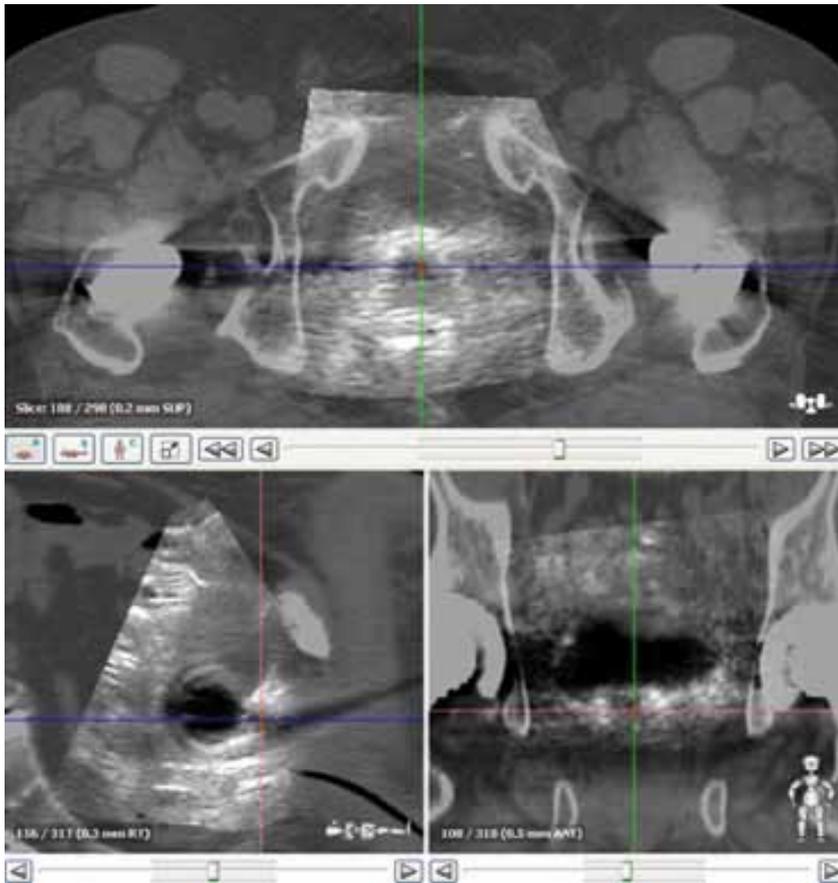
Coregistration between 3D ultrasounds and planning computed tomography.
